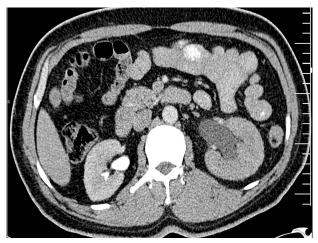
Computed tomography of the abdomen and pelvic showing dilatation of the left pyelocalyceal system and ureter. Dilatation of the left ureter is in the pelvic inlet.
